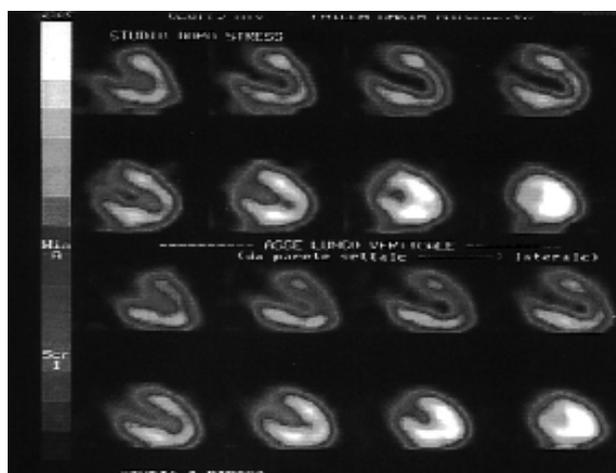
Myocardial scintigraphy showed an impaired septal perfusion in the same patient as figure 4 with left bundle branch block and normal coronary arteries.
